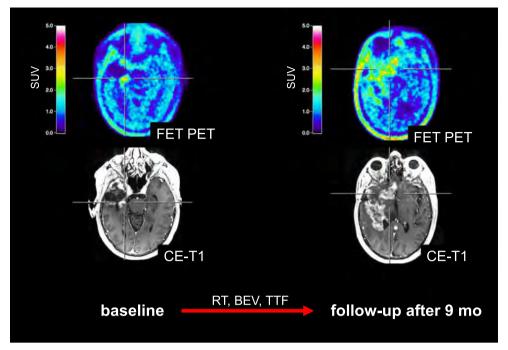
Hybrid PET/MR imaging including contrast-enhanced T1-weighted images and FET PET images in a 49-year-old man with glioblastoma at the time of recurrence and at follow-up 9 months later (patient 4). In spatial correspondence with the newly diagnosed contrast-enhancing lesion (*bottom left*), the FET PET image shows a metabolically active tumour (*top left*) with increased tumour-to-brain ratios (TBR_{max} 4.0, TBR_{mean} 2.3) and a metabolically active tumour volume of 9 ml.
